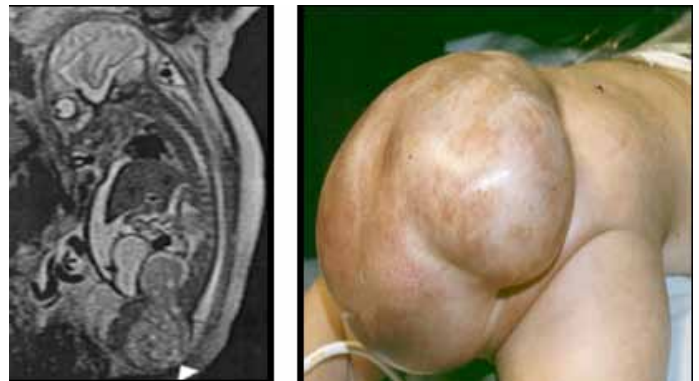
Sacrococcygeal teratoma (left: MRI).
